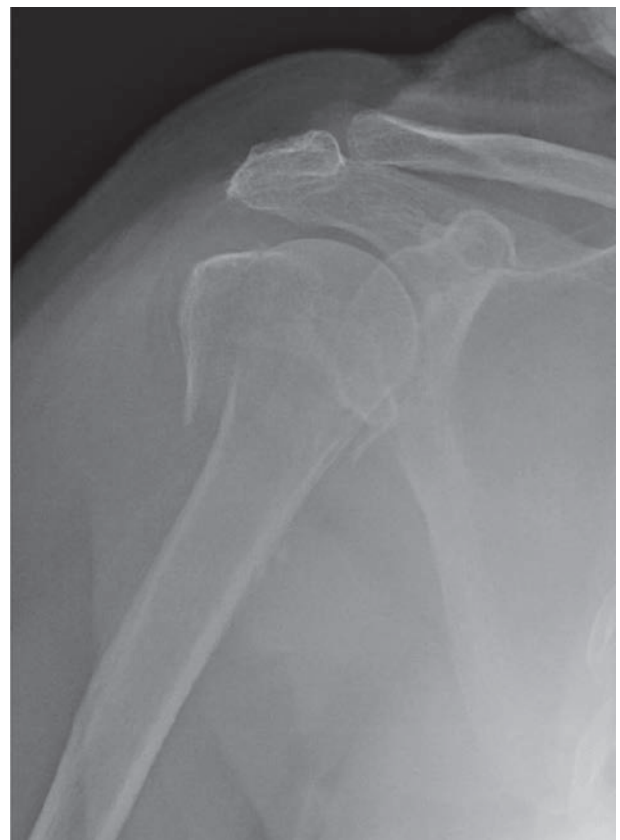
4 Radiographs of a 75-year-old woman with a four-part fracture osteosynthesis of the proximal humerus: the “sunset” sign is visible in the anteroposterior view
